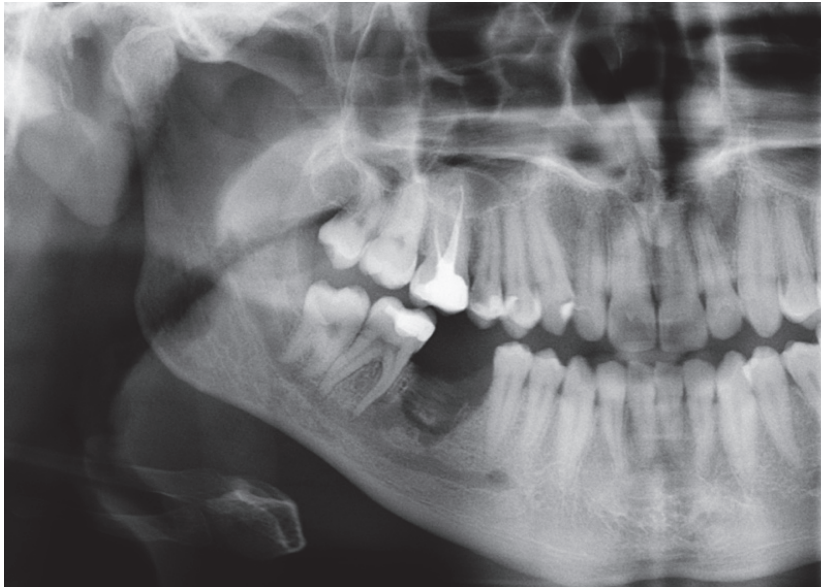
A postoperative radiograph of the LR6 during the follow-up visit.
